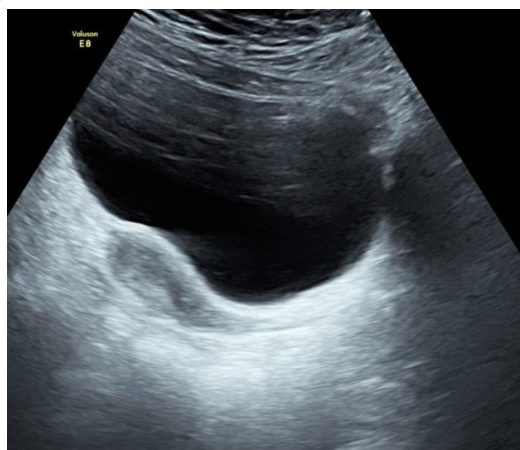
Ultrasonographic image of the uterus in an adolescent girl with uterine hypoplasia. A 16-year-old girl presented with complaints of amenorrhea and pelvic pain, which did not respond to nonsteroidal anti-inflammatory drugs (NSAIDs).
